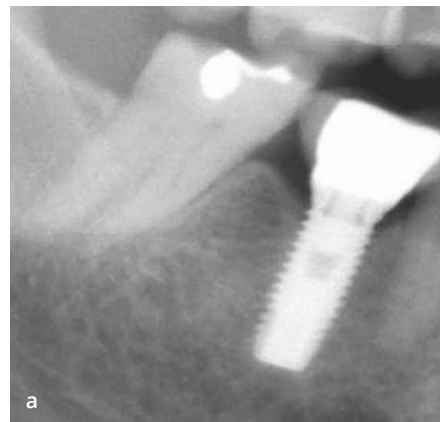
Even though excellent osseointegration was achieved, the underestimation of the overall TSL led to occlusal implant overload and implant failure. See the loss of tooth structure in the interval between the radiographs. Erosion eliminated the occlusal support of adjacent and contralateral teeth. The occlusal porcelain of the screw-retained implant crown had suffered from occlusal prematurities with repeated chipping and screw dislodgment, signs that had alerted the dentist to the issue. In this case the patient rejected any TW restorative treatment, resulting in progression to implant loss (a and b). (See more on this case in chapter 9.)
